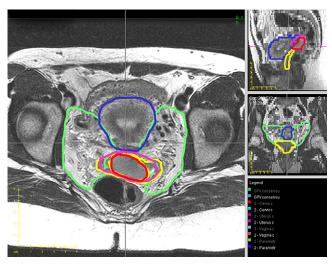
Axial and reconstructed sagittal and coronal views of T_2 -weighted MR images from a clinical contouring case showing 95% agreement contours for GTV (red), cervix (pink), vagina (yellow), parametria (green), and uterus (blue).
